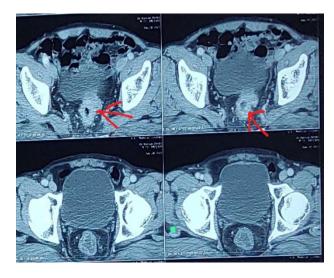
Patient with circumferential ulcer proliferative growth on CT scan
